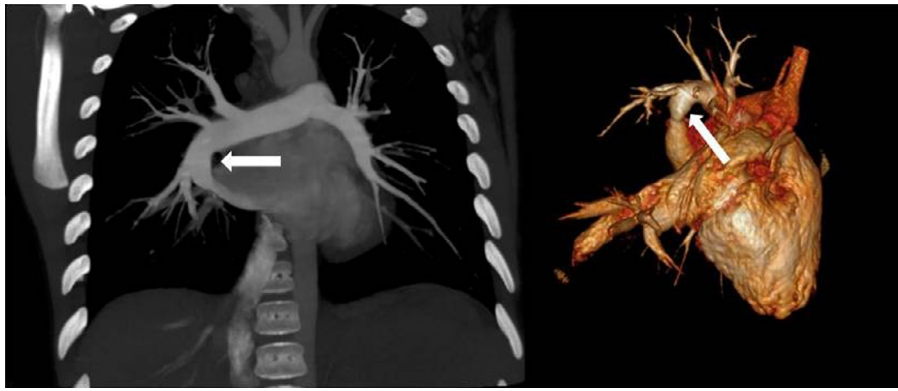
Computed tomography pulmonary angiogram with 3-dimensional reconstruction, arrow indicates direct fistulous communication between right lower lobe pulmonary artery and left atrium.
